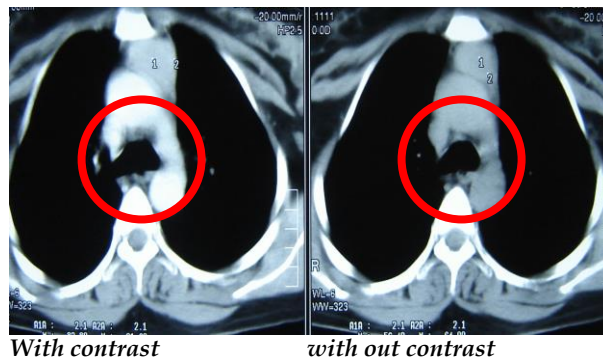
CT Scan Chest shows a well defined triangular soft tissue in anterior mediastinum.
